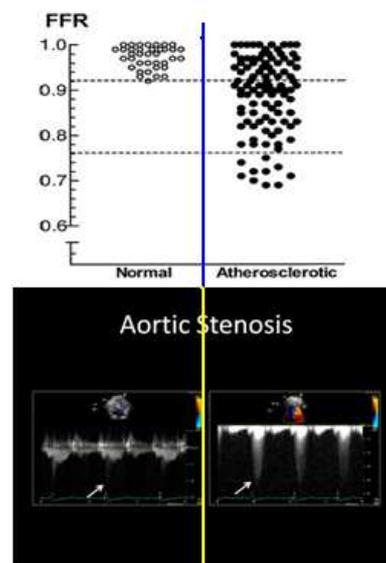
The difference between the normal and blockage aortic stenosis zone on relating FFR and Doppler scans.
